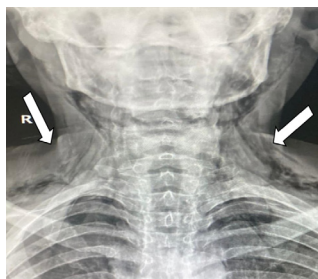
Neck x-ray showing subcutaneous emphysema.
